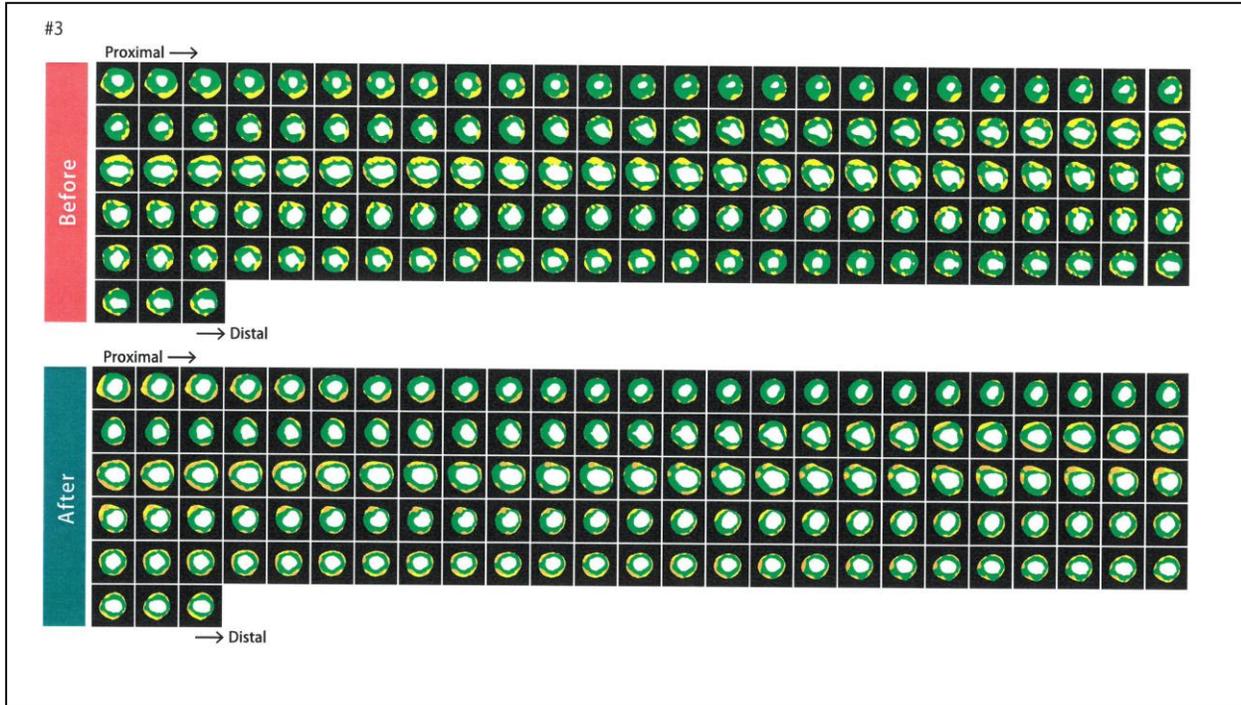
Supplementary coronary CT images with a color-coded display in Case 2 (panel B)
